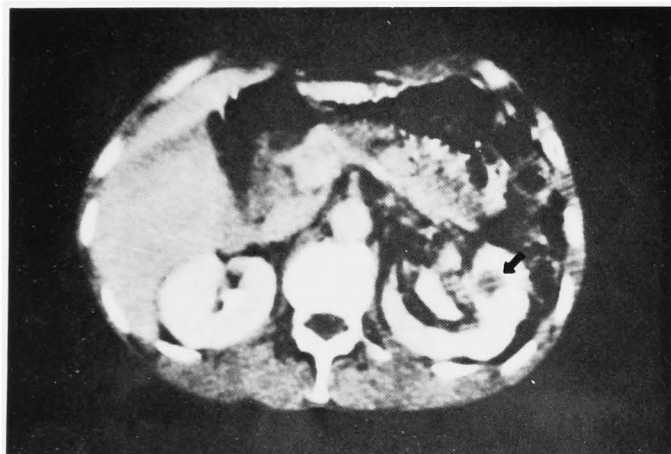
Case 2—Computed tomogram reveals a well-demarcated, spherical and low-density mass in the medullary area of the left enlarged kidney (arrow). This cystic region was retrospectively regarded as the position where a cavernous hemangioma was encountered.
